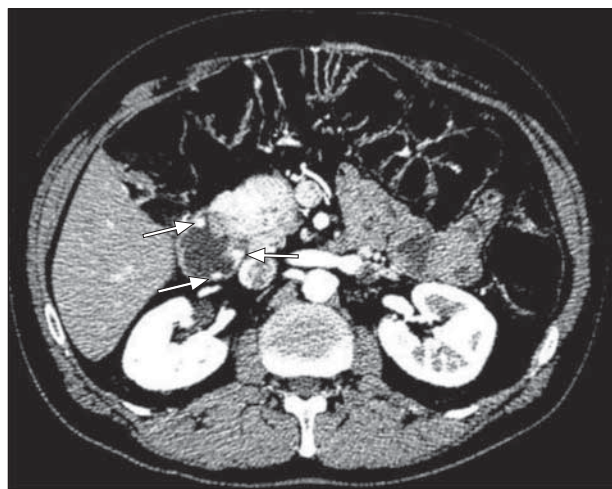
Computed tomography with intravenous and oral (VoLumen; EZ-EM Inc, Lake Success, New York) contrast detects pancreatic tumors and small duodenal tumors (arrows) consistent with neuroendocrine tumors.
